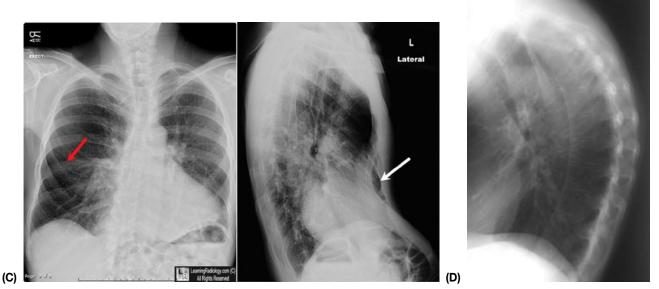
Chest deformities seen on chest radiography. (A) scoliosis, (B) kyphoscoliosis, (C) PE, (D) AS causing kyphosis. (A) © real444/Stock/Getty Images; (B) © Puwadol Jaturawutthichai/Shutterstock; (C) Published with permission from LearningRadiology.com; (D) Published with permission from WikiFoundry.
